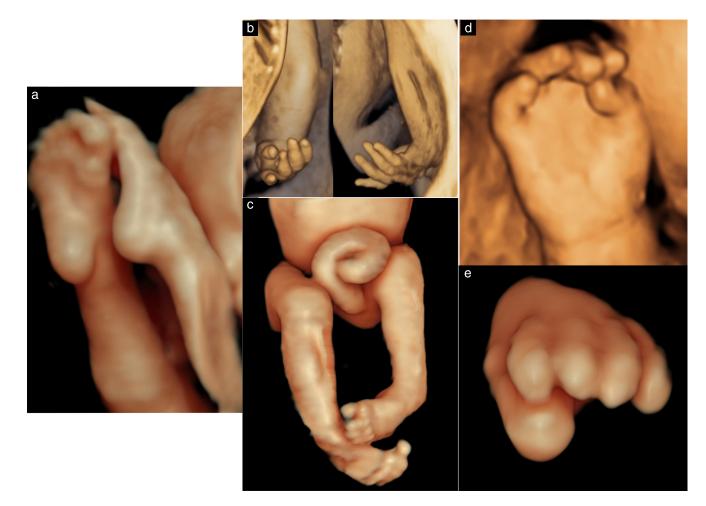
Overt signs of congenital hypotonia on ultrasound imaging: fetal joint contractures. (a) Plantar flexion in myotonic dystrophy, (b,c) waiter's tip sign (b) and bilateral clubfeet (c) in presumed hypotonia and (d,e) adducted thumb (d) and adducted toe (e) in nemaline myopathy Type 3.
